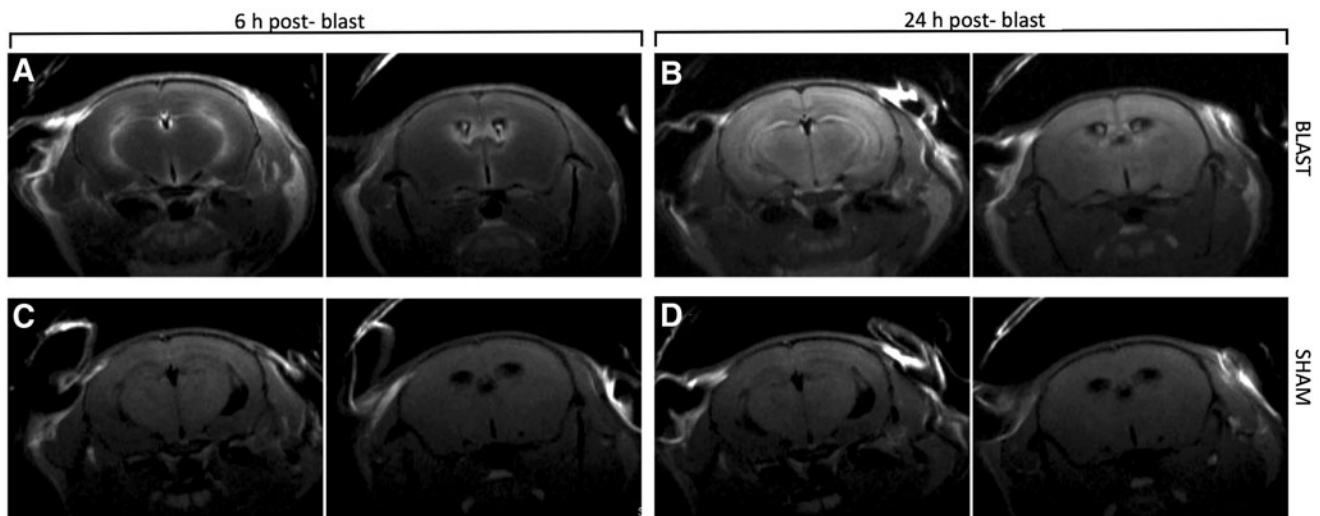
Six hours after blast and MnCl_2 injection, positive contrast is markedly increased in ventricular and periventricular areas (A). Manganese-enhanced magnetic resonance imaging performed 24 h after blast reveals a diffuse pattern of contrast increase throughout the brain parenchyma (B). Uptake of contrast agent is significantly less prominent in sham controls at both time-points (C, D).
